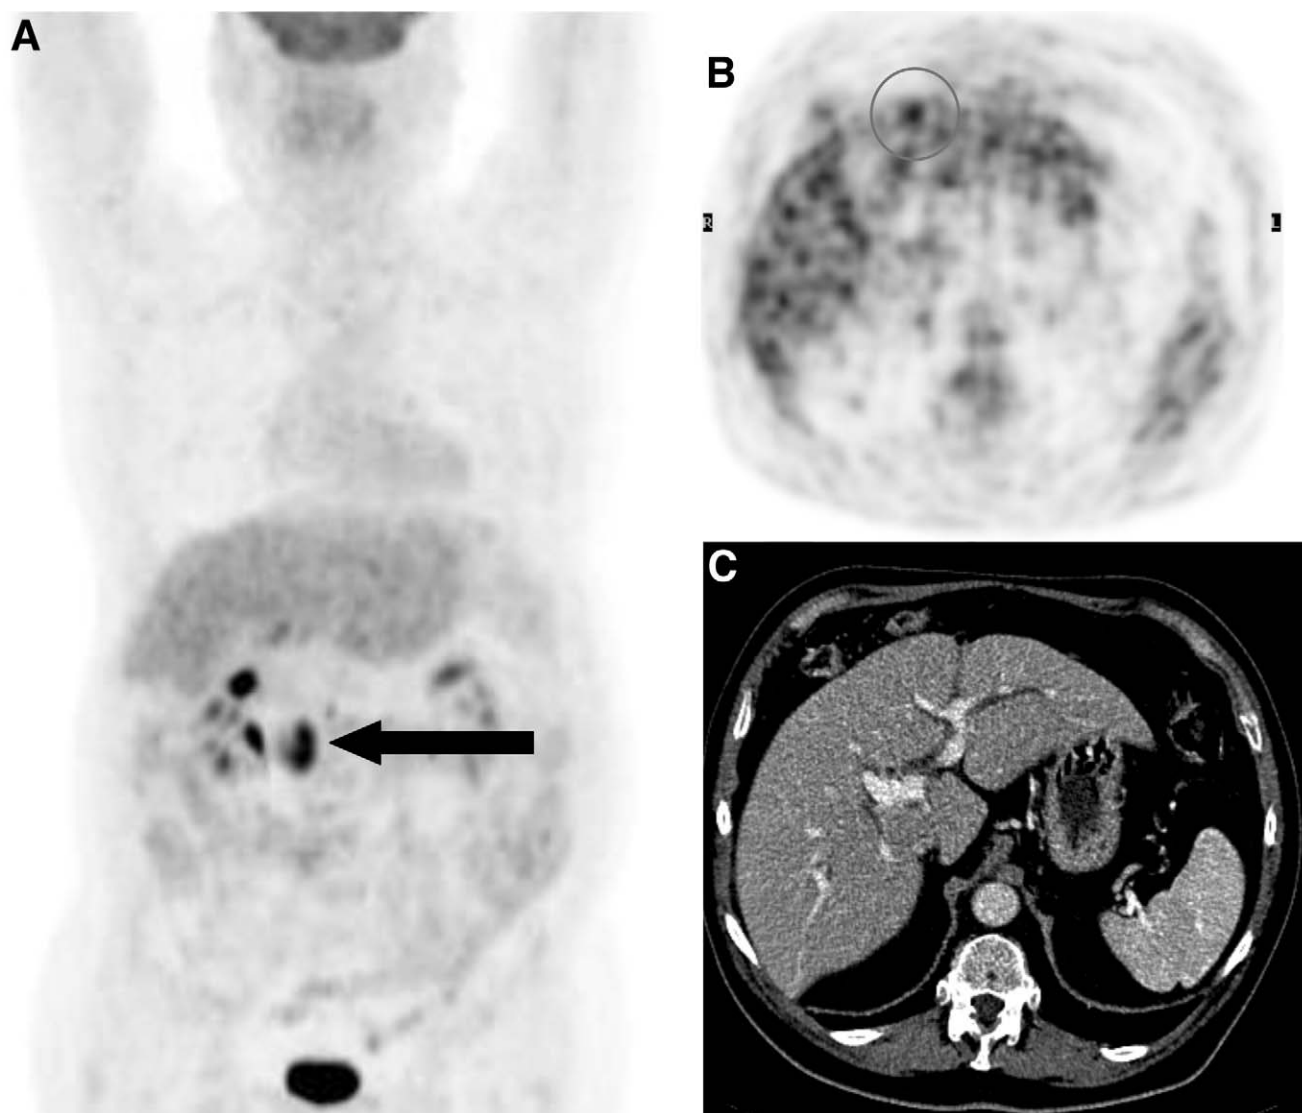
An FDG-PET scan was performed as part of preoperative staging of an operable tumor of the head of the pancreas. The pancreatic lesion can be clearly seen on the MIP image (A; black arrow). The PET axial slice (B) also demonstrates a subcentimeter liver metastases (circle) not previously seen on a staging contrast enhanced CT (C). The patient was therefore treated nonsurgically by chemotherapy.
